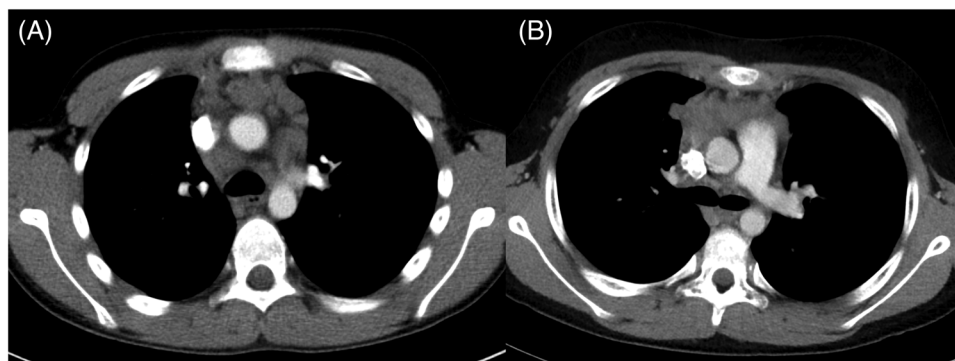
Computed tomography (CT) appearance with mass effect and inhomogeneous parenchyma concerning for malignancy of (A) rebound thymic hyperplasia (RTH) in a 15-year-old male patient, and (B) thymic lymphoma relapse (LR) in an 11-year-old male patient.
